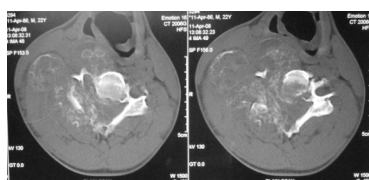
A) CT&MR images of C 5 vertebra show GCT with secondary ABC
